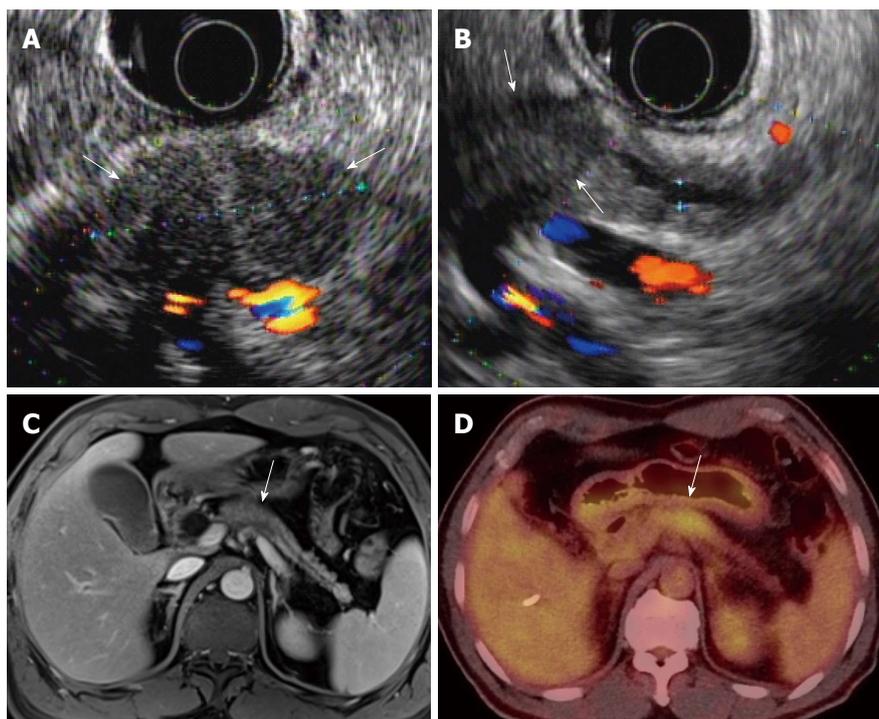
A 58-year-old, male patient with pancreatic body cancer with typical imaging findings. A, B: Endoscopic ultrasonography shows an approximately 3-cm, hypoechoic mass (arrows) in the pancreatic body with distal pancreatic duct dilatation; C, D: The mass (arrow) shows hypointensity on portal-venous-phase, contrast enhanced MR and hypermetabolism on PET/CT, respectively. MR: Magnetic resonance; PET: Positron emission tomography; CT: Computed tomography.
